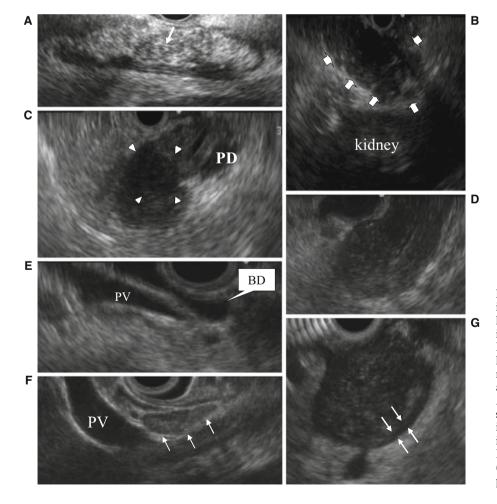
A Endoscopic ultrasound (EUS) image showing hyperechoic foci and hyperechoic strand (arrow) in an autoimmune pancreatitis (AIP) patient.
